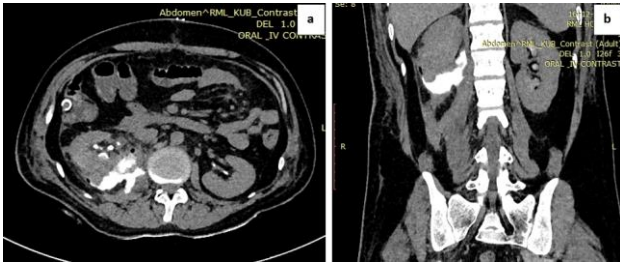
a) and b) Stab injury right flank: Axial and coronal reformatted CT in delayed phase diffusion of extravasated material into retroperitoneum.
